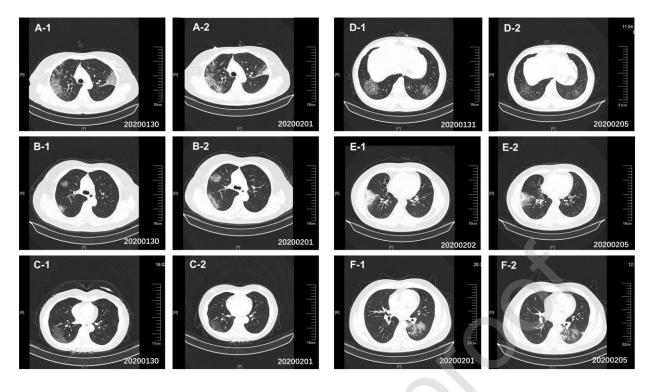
CT scans of the 2019-nCoV nucleic acid–detected positive patients.
